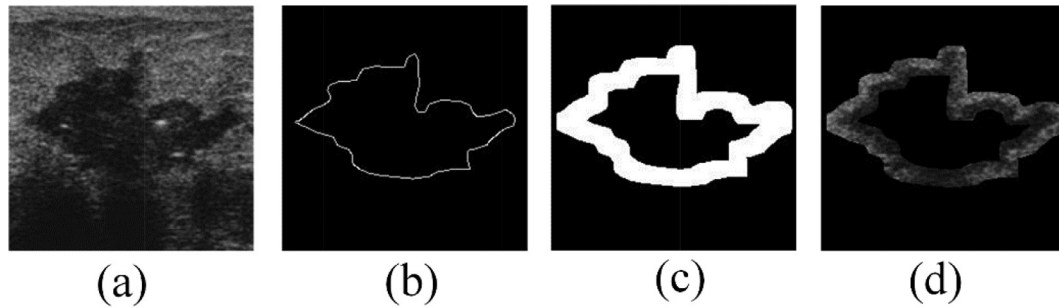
Extracting the edge blur information of lesions: (a) Original breast ultrasound image; (b) Edge complexity image of the lesion; (c) Mask image of the edge of the lesion area; (d) Edge blur image of the lesion
